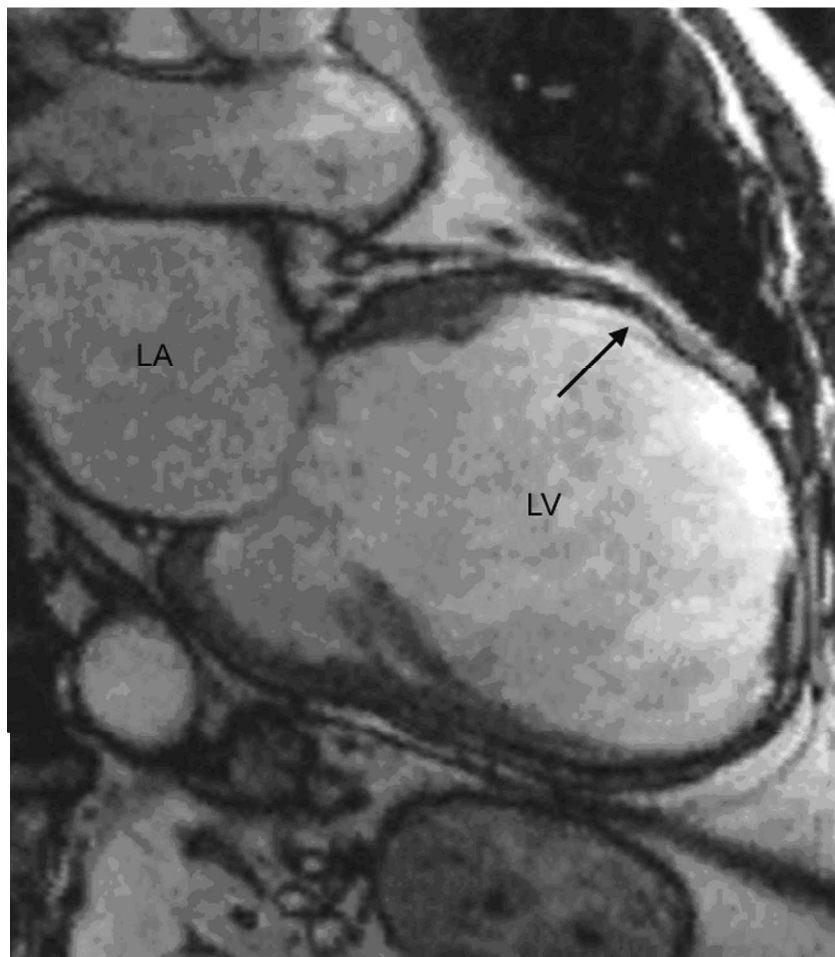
Cardiac magnetic resonance image with gadolinium enhancement demonstrating a dilated poorly contractile left ventricle (LV) with extensive scarring (arrowed) due to previous myocardial infarction.
